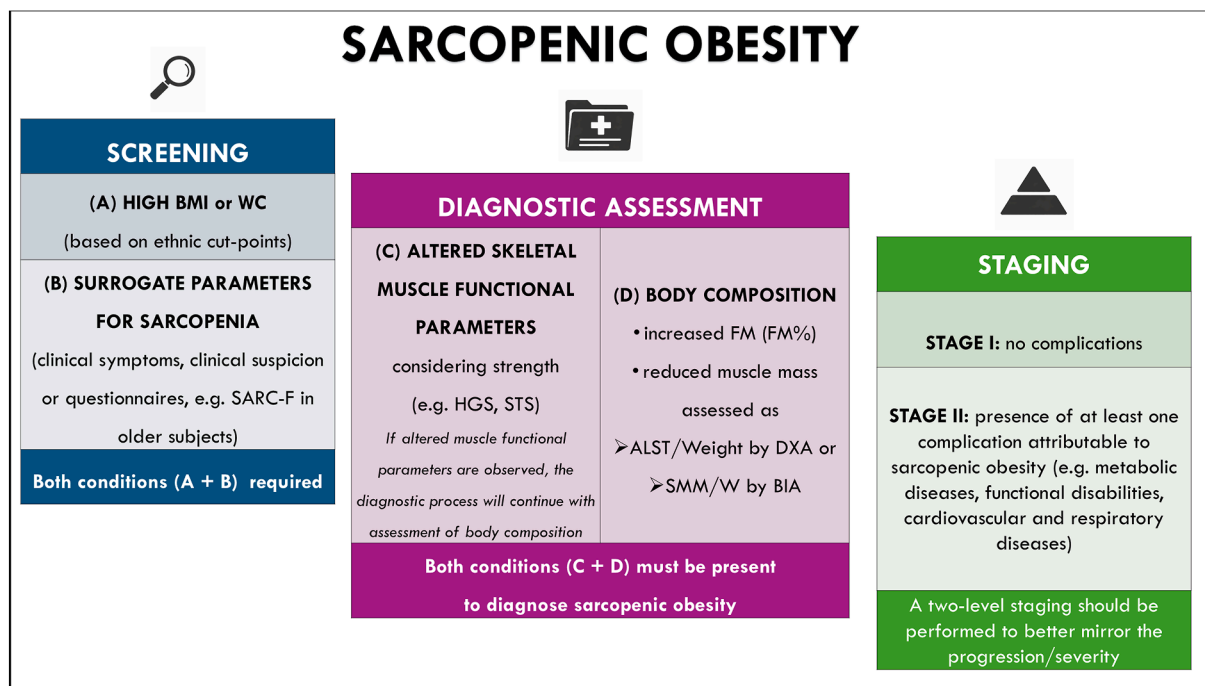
Diagnostic procedure for the assessment of sarcopenic obesity. Adapted from [1] Donini et al. *Obes Facts* 2022; 15:321–335 and [2] *Clin Nutr* 2022 Apr; 41 (4):990–1000. ALST: appendicular lean soft tissue (previously reported as appendicular lean mass adjusted to body weight ALM/W); BIA: Bioelectrical impedance analysis; BMI: Body mass Index; DXA: Dual-energy X-ray absorptiometry; FM: Fat Mass; HGS: handgrip strength; SMM/W: skeletal muscle mass adjusted to body weight; STS: sit-to-stand test (previously reported as chair stand test); WC: Waist circumference.
